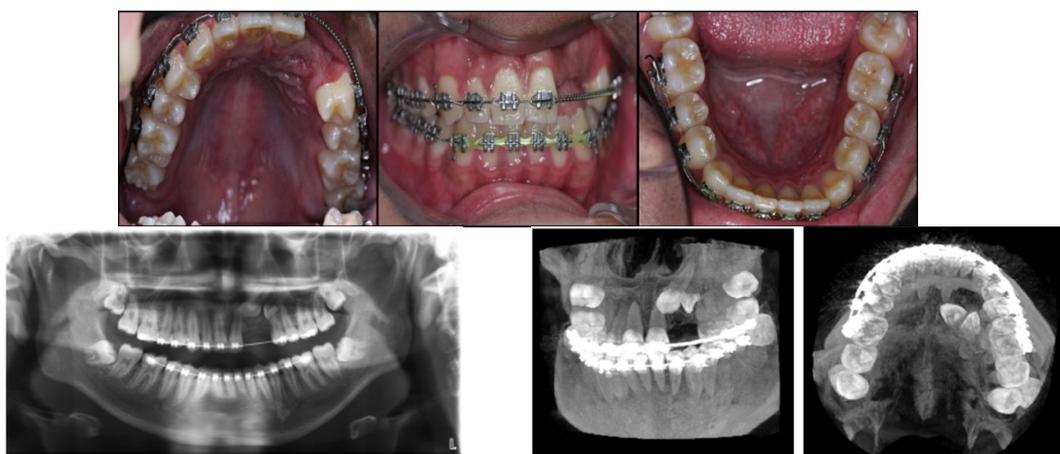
Fixed appliance on upper and lower teeth with open coil spring between left upper central incisor and first premolar, cone beam computed tomography (CBCT) and orthopantomogram (OPG) during orthodontic treatment
